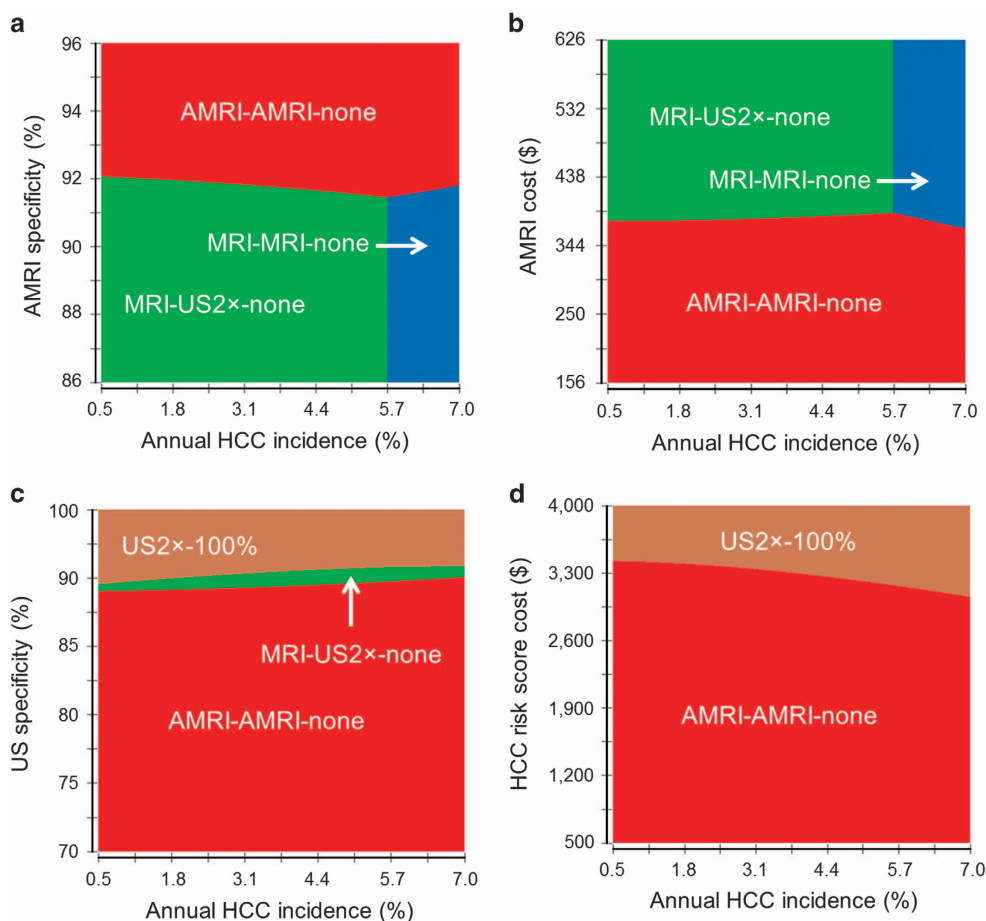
Two-way sensitivity analysis of annual hepatocellular carcinoma (HCC) incidence vs. variables affecting cost-effectiveness of risk-stratified HCC screening. Overall HCC incidence is varied along with model parameters, (a) abbreviated MRI (AMRI) specificity, (b) AMRI cost, (c) ultrasound (US) specificity, and (d) HCC risk biomarker cost, with the greatest effect on incremental cost-effectiveness ratio of non-dominant, cost-effective risk-stratified strategies.
